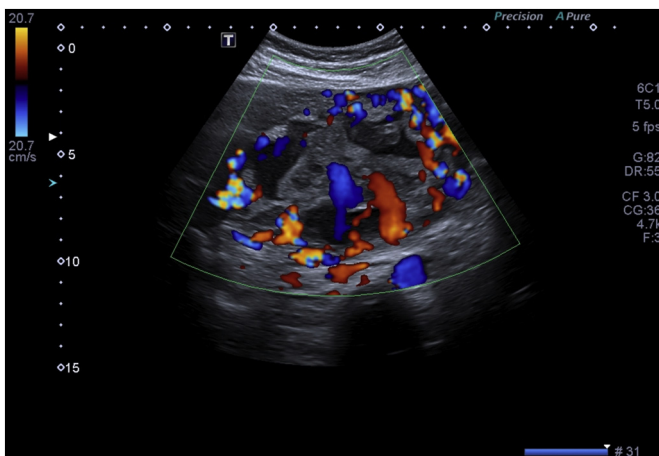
Abdominal ultrasound: fund posterior placenta with many large venous lakes shown with doppler colour.
